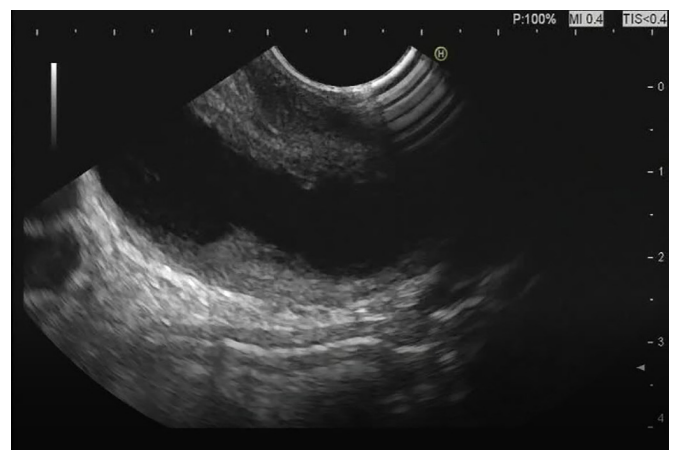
Linear endoscopic ultrasound image of sludge in the gallbladder.
